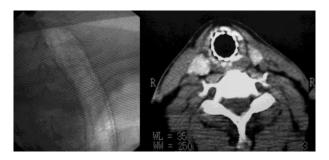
a-Plain X-ray showing a stent place b- CT scan showing the stent in place
